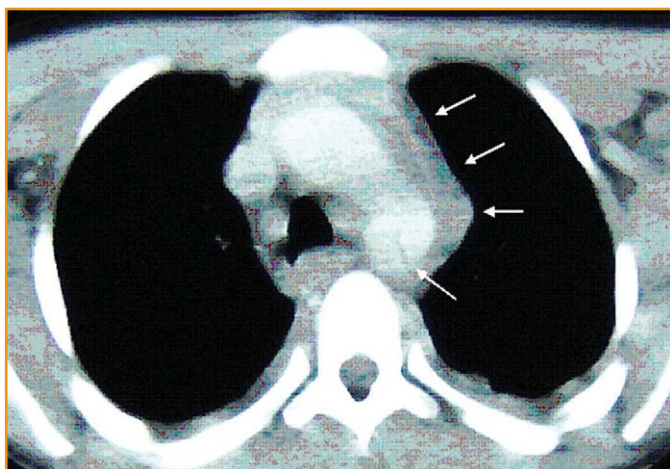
This CT thorax with contrast shows an intimal flap in the descending aorta with a periaortic fluid collection.
